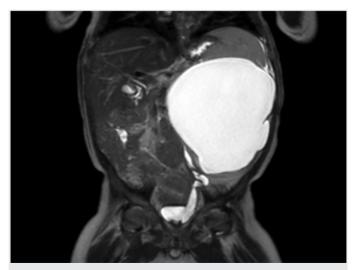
Coronal thick slab T2-weighted magnetic resonance urography shows a left-sided cystic kidney mass in the upper pole. A low lying dilated and tortuous left upper moiety ureter is seen
